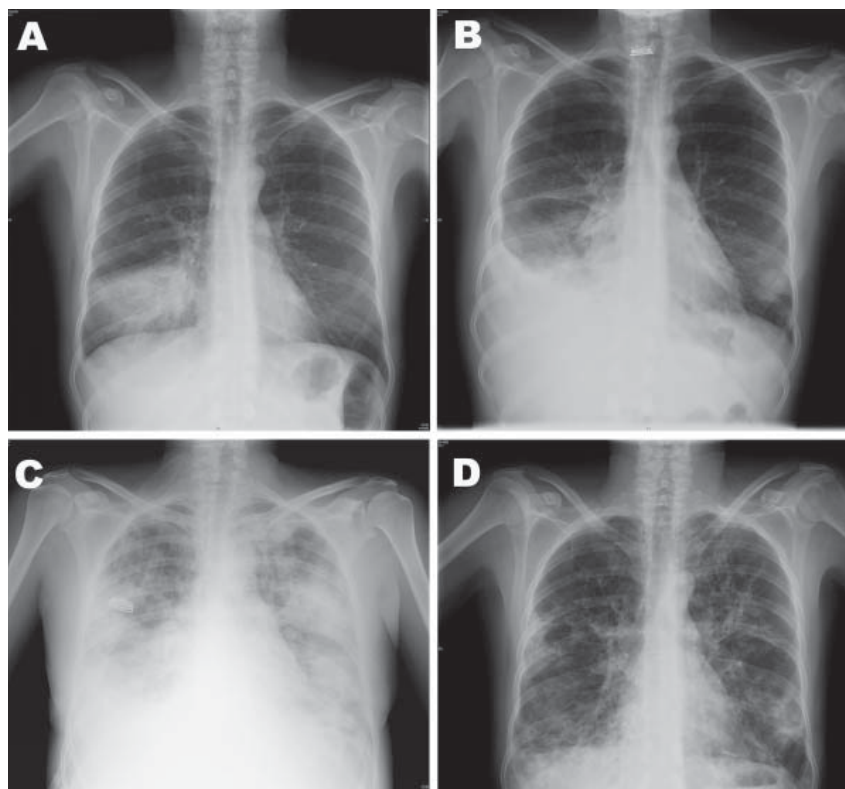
Chest radiographs of 37-year-old, HIV-positive woman with severe pandemic (H1N1) 2009 virus infection, 2009. A) June 24, alveolar infiltrate in the right lower lobe. B) July 3, minimal pleural effusion, alveolar infiltrate on right lower lobe, and possibly left lower lobe infiltrate. C) July 6, bilateral alveolo-interstitial infiltrates. D) July 29, bilateral peribroncovascular thickening with fibro-cicatricial changes; conserved lung volumes.
